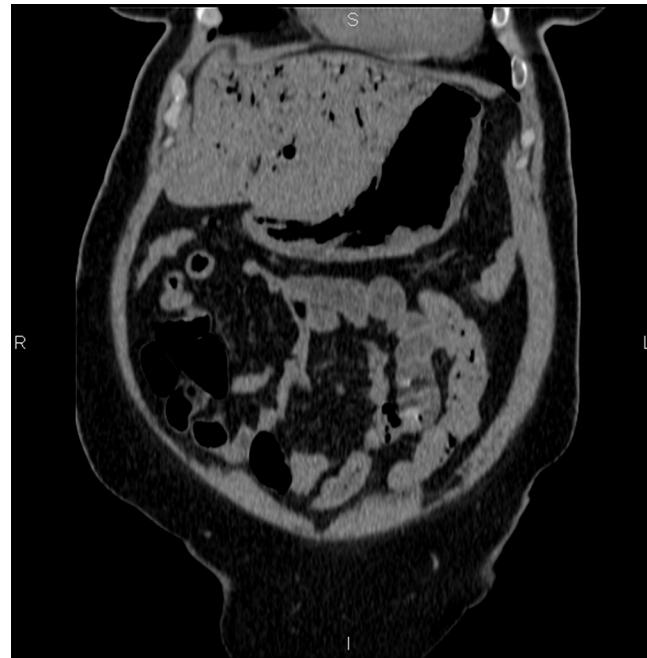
Abdominal CT scan without contrast. Coronal reconstruction: emphysematous gastritis and portal system.
